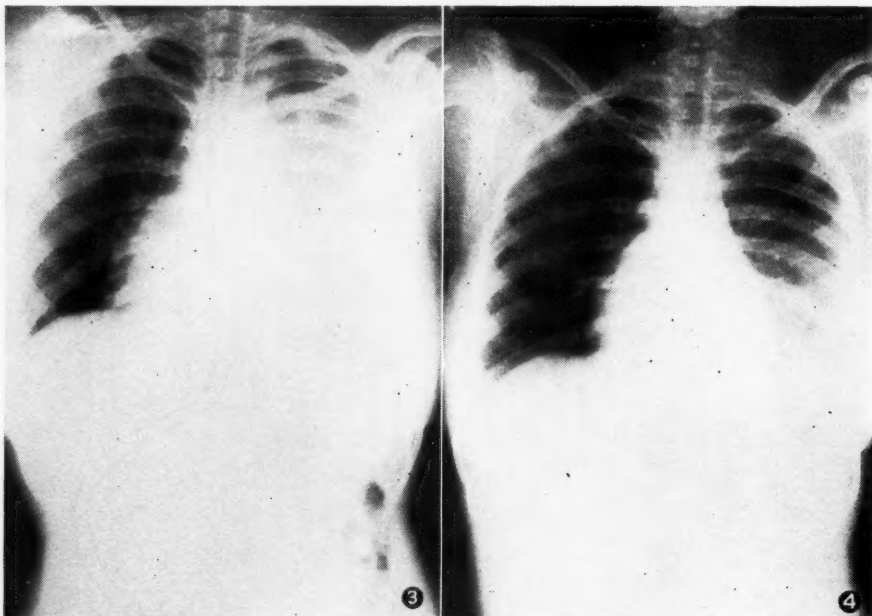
Post-operative radiograph showing a stomach air bubble well below diaphragm, and disappearance of paracardiac air shadow.
